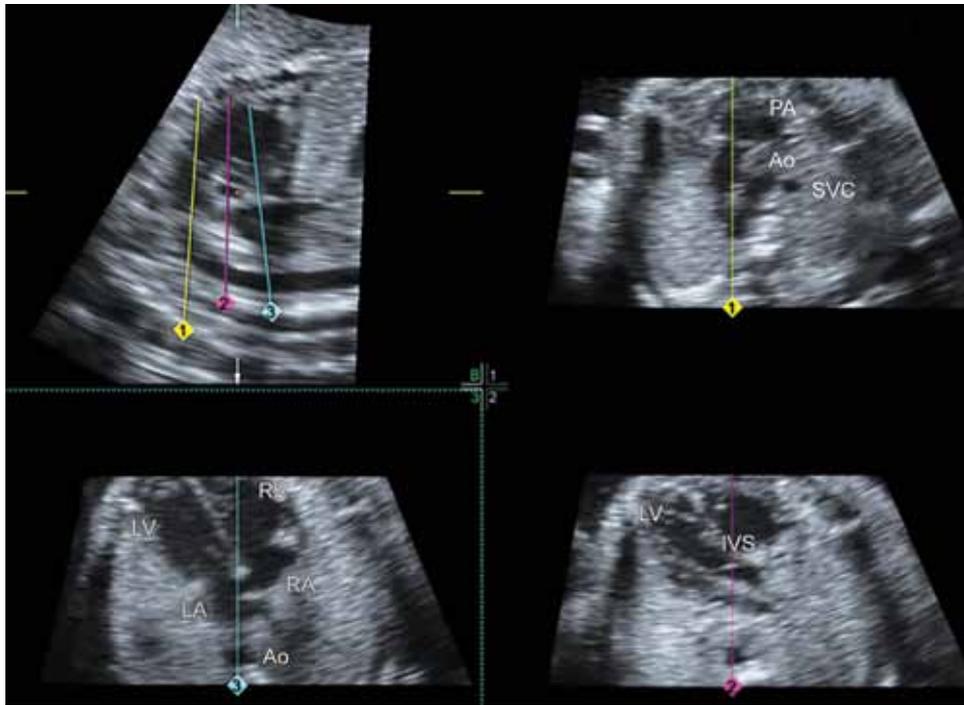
Obtaining standard echocardiographic planes by four-chamber view and swing technique (FAST) of Omniview® software (General Electric Medical Systems, Zipf, Austria). Taking the plane of the ductal arch as a standard, three straight lines are positioned. The first line (yellow) goes through the center of the pulmonary artery; the second line (pink) goes through the center of the aorta, and the third line (blue) is adjacent to the outer edge of the aorta. The program automatically provides the three-vessel plus trachea plane (upper left), the five-chamber plane (lower left) and the four-chamber plane (lower right) (LV: Left ventricle; RV: Right ventricle; LA: Left atrium; RA: Right atrium; Ao: Aorta; PA: Pulmonary artery; SVC: Superior vena cava; IVS: Interventricular septum)
